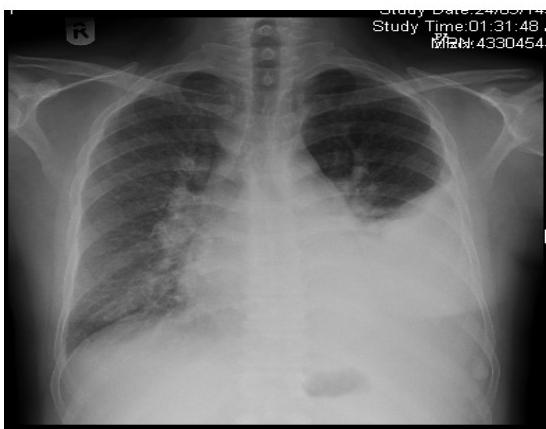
chest x-ray showing left pleural effusion with left lower lobe atelectasis.
